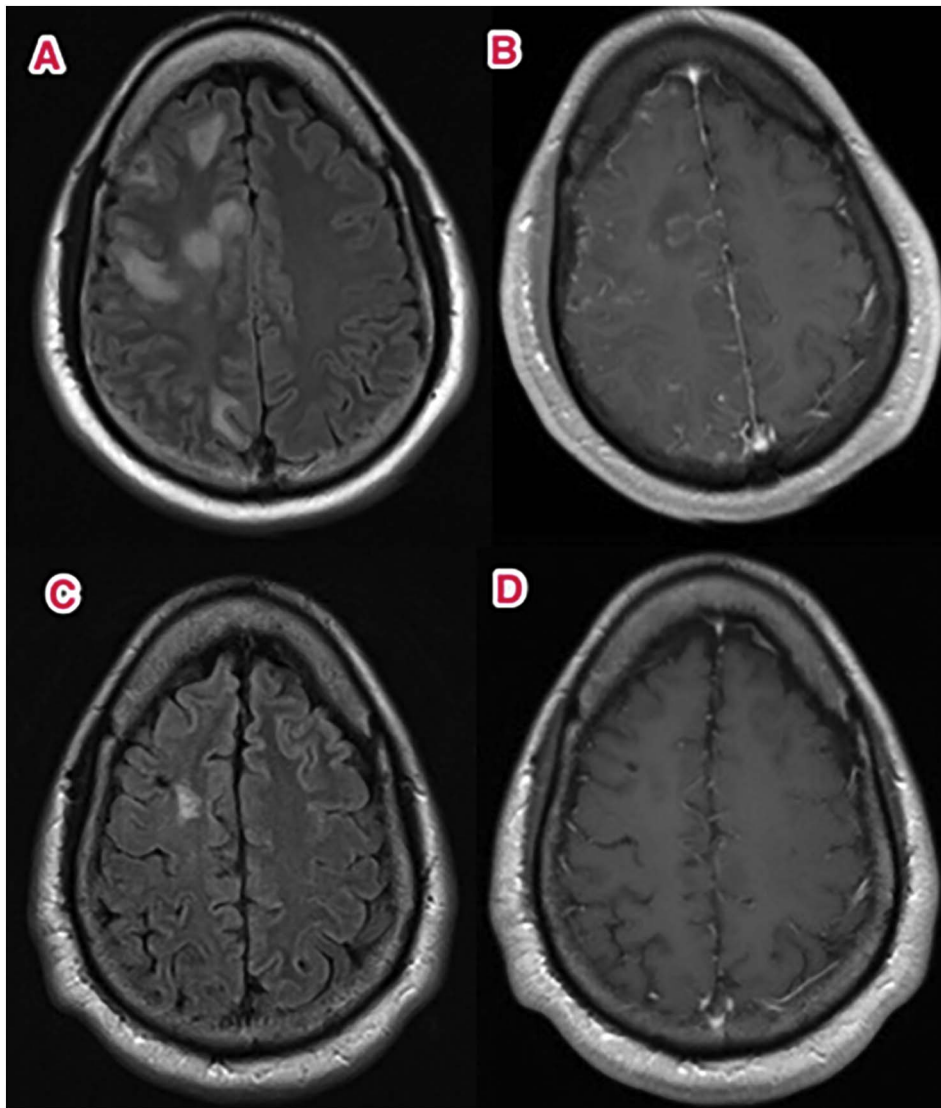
MRI brain (FLAIR and T1 with contrast).
